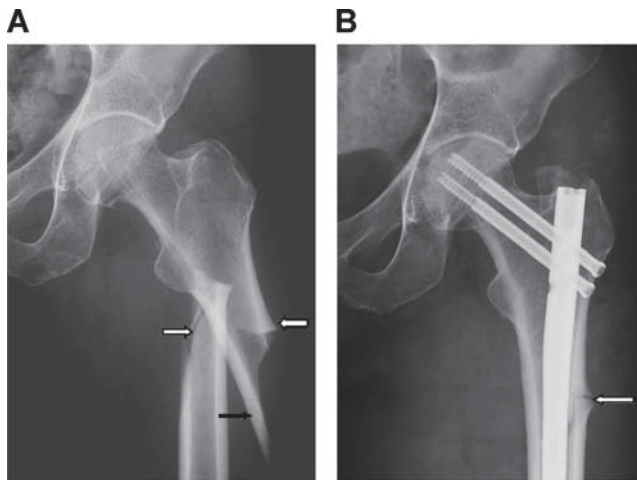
Anteroposterior (AP) radiographs showing an atypical femoral shaft fracture (A) pre- and (B) postoperatively from the same individual. Note the oblique and transverse components (*white arrows*) and a medial “spike” (*black arrow*) on the preoperative
